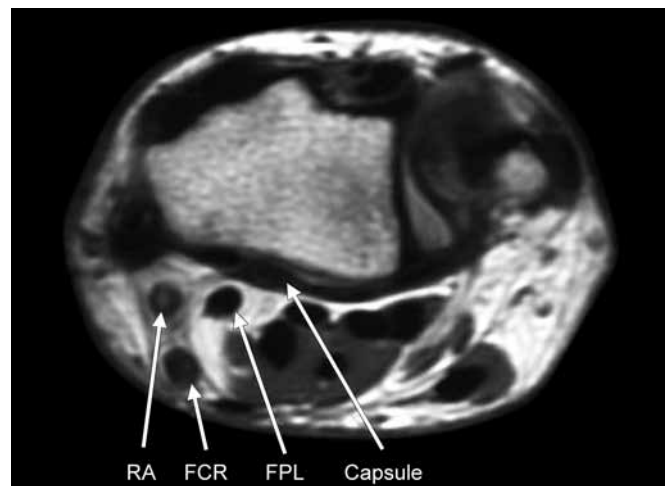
MRI demonstrating proximity of vital structures to the volar wrist capsule—RA: Radial artery; FCR: Flexor carpi radialis; FPL: Flexor pollicis longus
